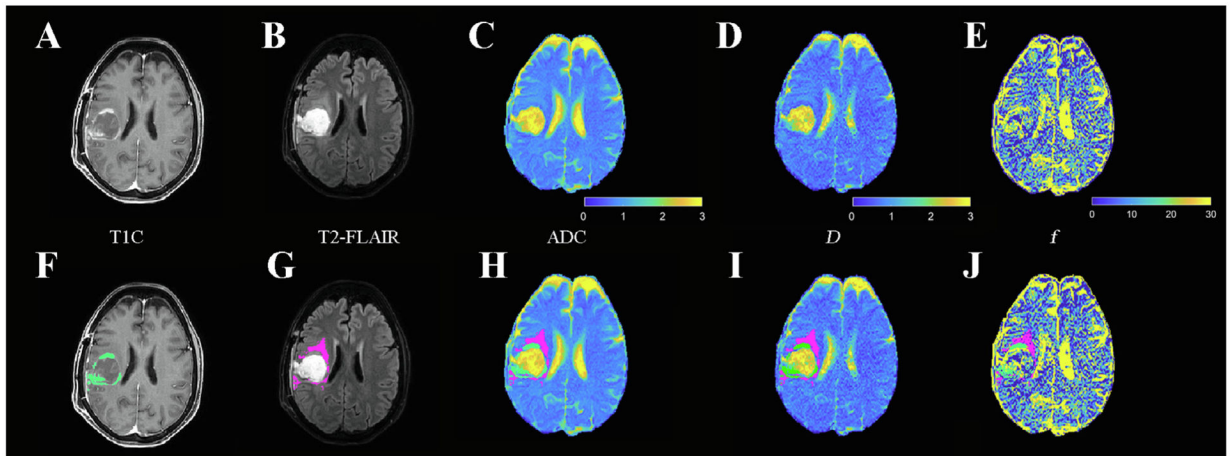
Images of a patient included in the study. Contrast-enhanced T1 image (A), T2-FLAIR image (B), ADC map (C), D map (D) and f map (E). Region of interest (green) of the enhancing parts of the mass (F), region of interest (magenta) of non-enhancing T2-FLAIR hyperintensity (G), with both regions of interest overlaid on ADC map (H), D map (I) and f map (J). ADC and D color bar scale is $\times 10^{-3} \text{ mm}^2/\text{s}$, while f color bar is shown in percent.
